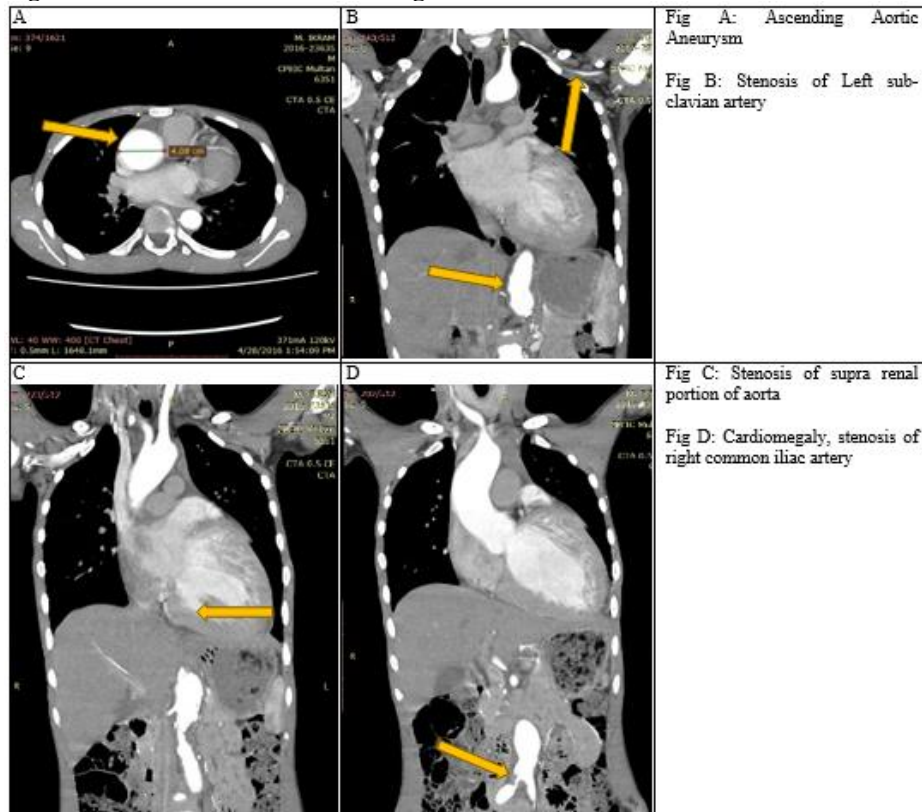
CTA Pictorial Findings of Patient D
